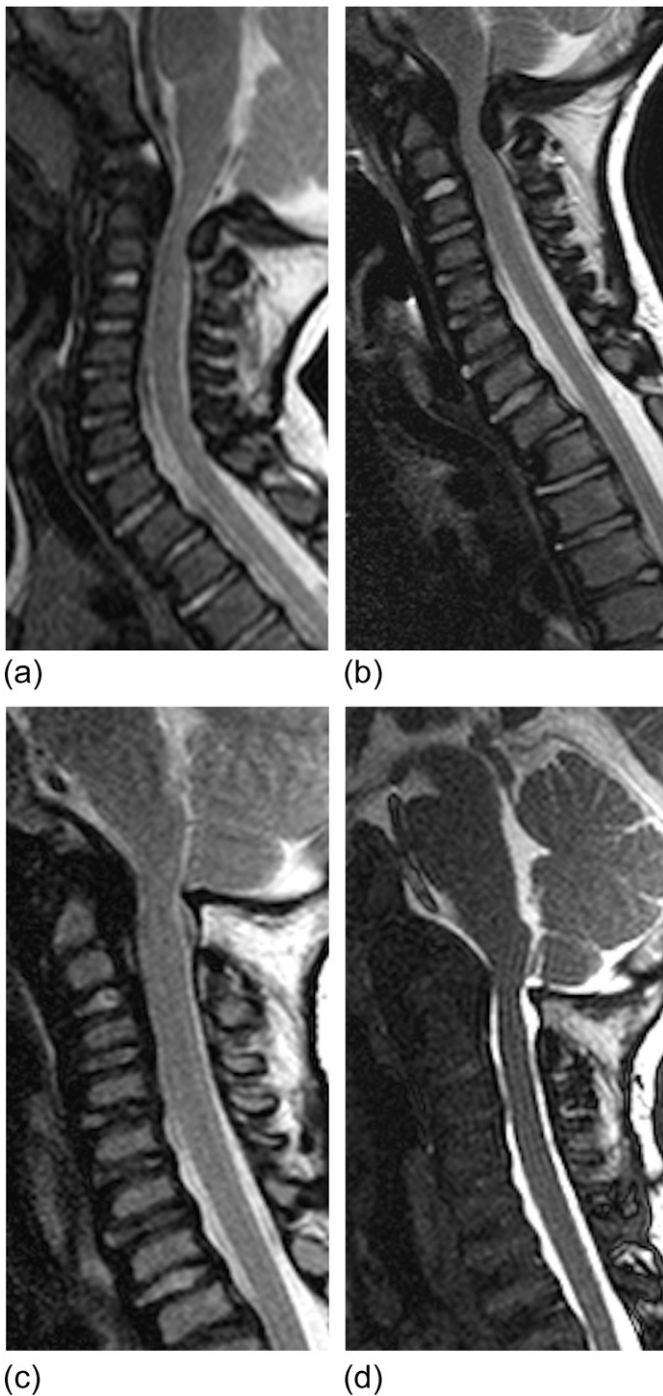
An MPS VI subject with spinal cord compression at 1 year 7 months develops progressive stenosis and undergoes cervical decompression without fusion with excellent outcome. (a) and (b) Cervical spine MRI. T2 TSE sagittal at 1 year 7 months of age shows odontoid dysplasia, thickening of the cruciate ligaments, and hypoplasia of C1, all resulting in focal spinal stenosis measuring 5 mm and cervical cord compression. A follow-up study at 3 years 9 months of age shows progressive stenosis at C1 which now measures 4 mm with cord compression and complete effacement of CSF. Surgical decompression was performed. (c) Cervical spine MRI. Post-surgical T2 TSE performed 6 years later at 10 years of age shows adequate decompression with preservation of normal T2 signal within the cord. Note the pointed dural fold at the posterior margin of the foramen magnum, a post-surgical finding which can be monitored for progression. (d) Cervical spine MRI. This bTFE sagittal cine sequence offers superior depiction of flowing CSF at the foramen magnum.
